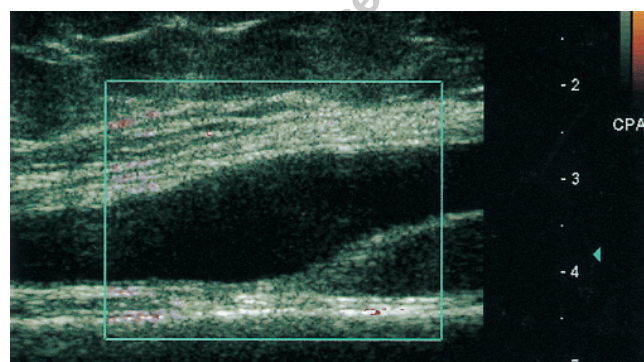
Osteoarthritis of knee joint (79-year-old woman): suprapatellar longitudinal scan (standard scan⁵) lateral recessus showing effusion with no power Doppler signal.
